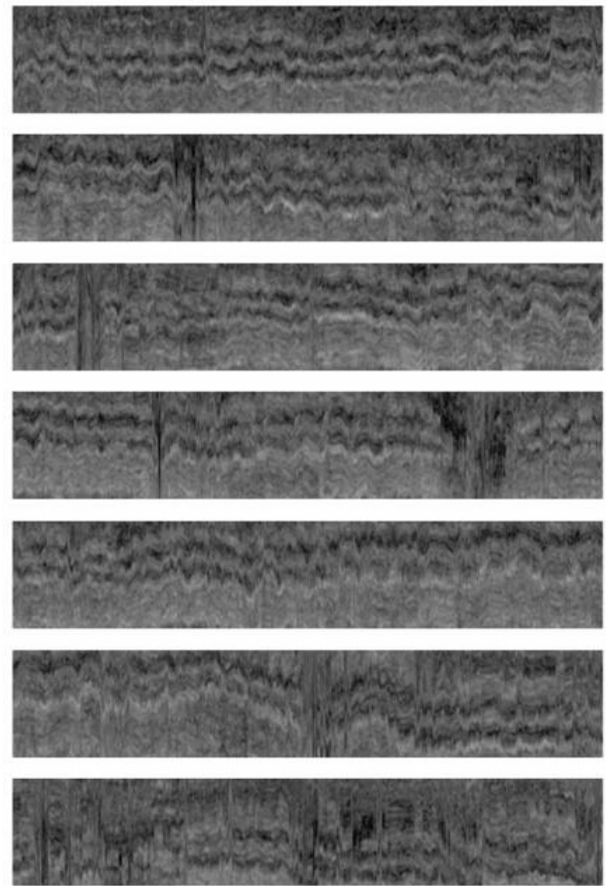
Concatenated time series data lines from continuous real-time ultrasonographic images of contractile activity in the lining of the uterus during sexual arousal and orgasm (© R. A. Pierson)
